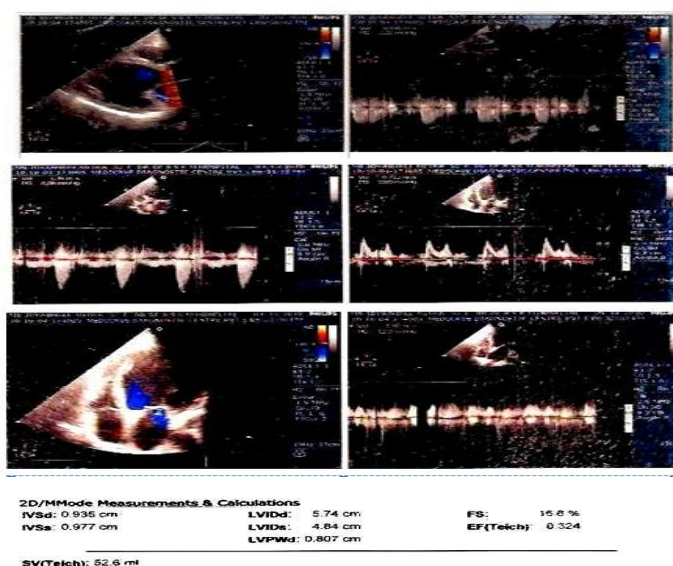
The echocardiograph of an IHD patient
